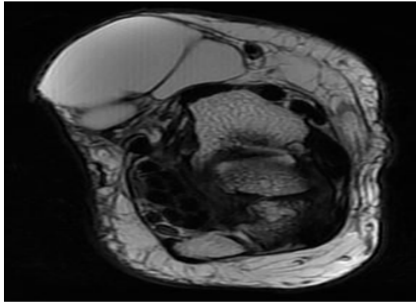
T2-weighted Sagittal View of the Left Wrist. The Ganglion Has 3 Lobes
